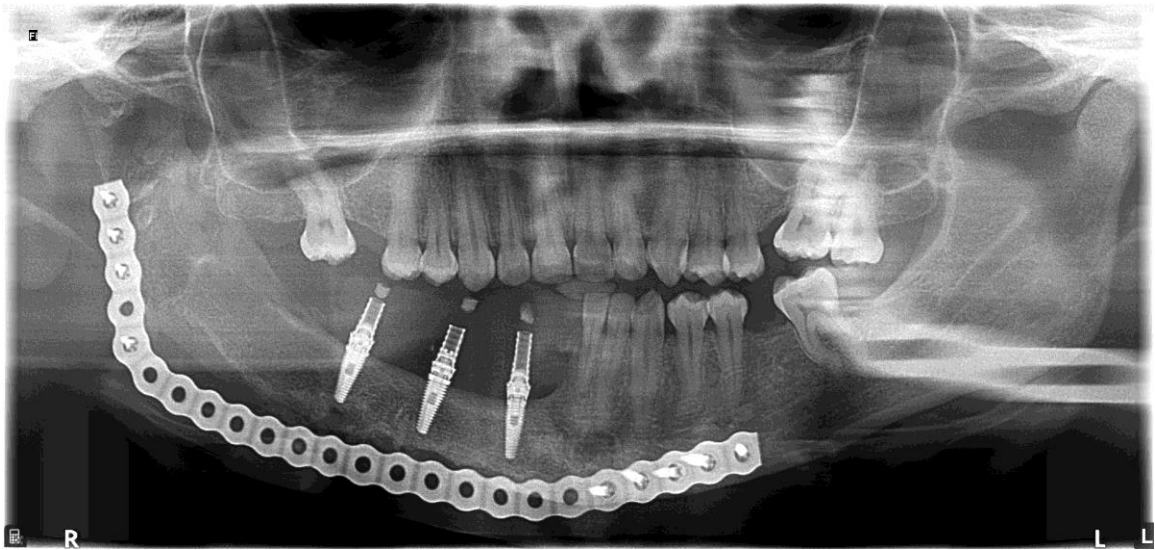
Post implant loading x-ray.
